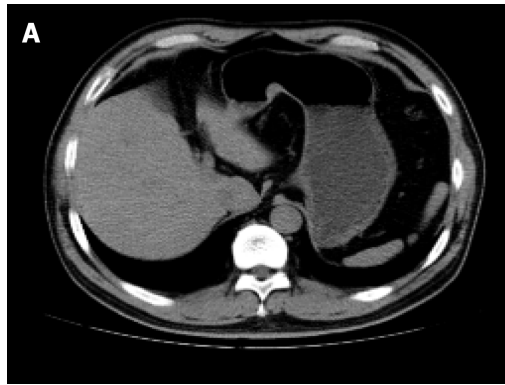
Abdominal computed tomography findings. A 15 mm × 12 mm protruding nodule was shown on the lesser curvature of the stomach.
